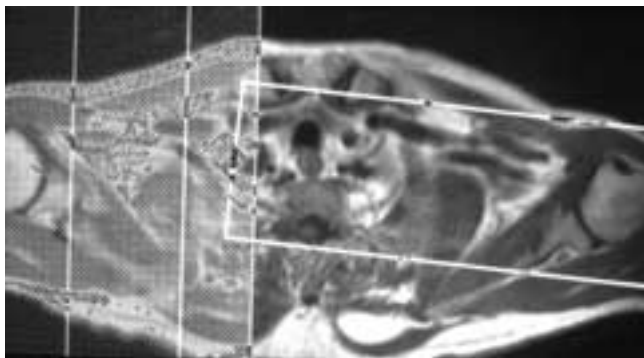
Axial scout localizer used to obtain an oblique coronal T1-weighted MR image. Note that these images are obtained parallel to the course of the subclavian and axillary arteries.
